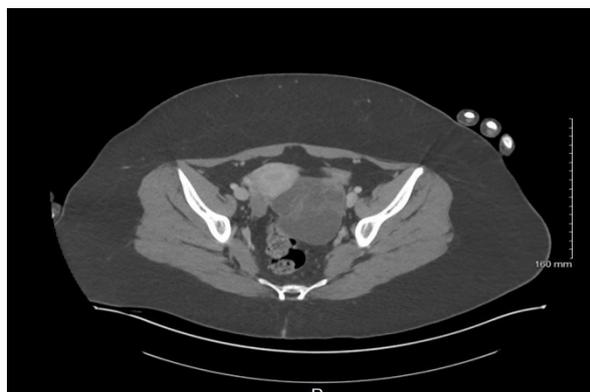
CT Abdomen/Pelvis: 7.8cm solid-cystic left adnexal mass
